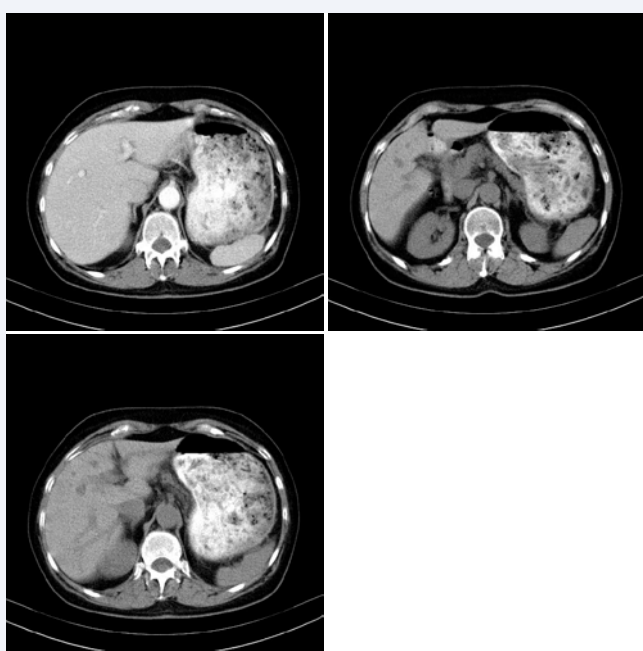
Axial computed tomography (CT) scans of the upper abdomen after oral contrast agent, with and without IV contrast agent administration; at the upper (A) and lower (B) part of the liver show an increase in liver density with normal attenuation of the other organs. On the axial CT scan with IV contrast agent (C); Hyperdense liver parenchyma can be seen.
